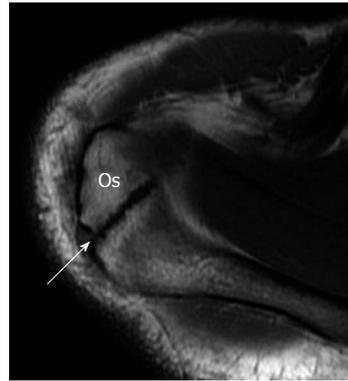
Os acromiale. Axial T1-weighted image showing the os acromiale.
